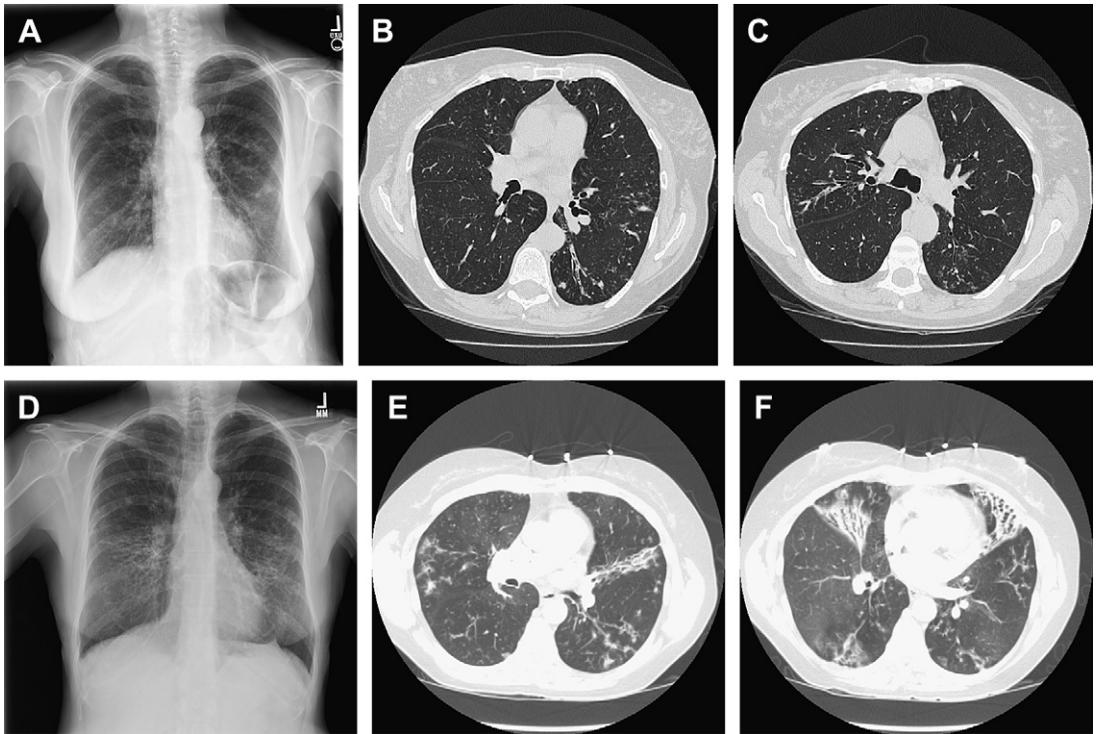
(A) P/A chest radiograph of a 62-year-old woman with bronchiectasis and *M avium* complex lung disease, showing bilateral primarily midlung nodular and reticulonodular densities. (B, C) HRCT images of the same patient demonstrating bronchiectasis, nodular densities, and tree-in-bud densities. (D) Posteroanterior (P/A) chest radiograph of a 74-year-old woman with bronchiectasis and *Mycobacterium avium* complex lung disease, showing bilateral primarily midlung nodular and reticulonodular densities. (E, F) High-resolution chest CT (HRCT) images of the same patient demonstrating bronchiectasis with destruction of the right middle lobe and lingula, nodular densities, and tree-in-bud densities characteristic of mycobacterial lung infection.
